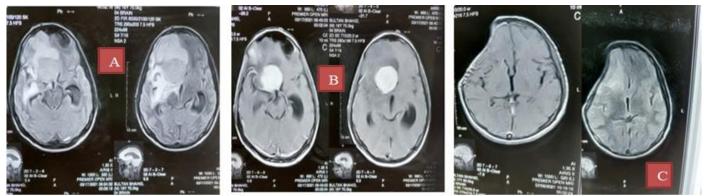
(A & B): Preoperative MRI scan shows a large mass with Dural attachment causing edema and midline shift (C) Postoperative MRI brain showing a defect in skull. No mass or associated edema and midline shift is seen.
